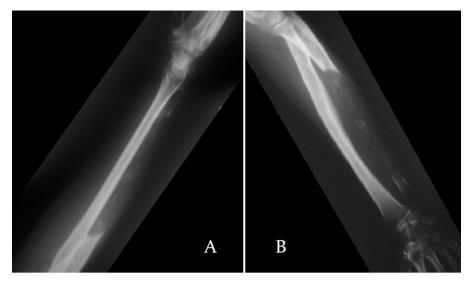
(A) Lateral and (B) AP radiographs of the forearm demonstrating a large lytic lesion throughout the ulnar shaft caused by metastatic breast cancer.
